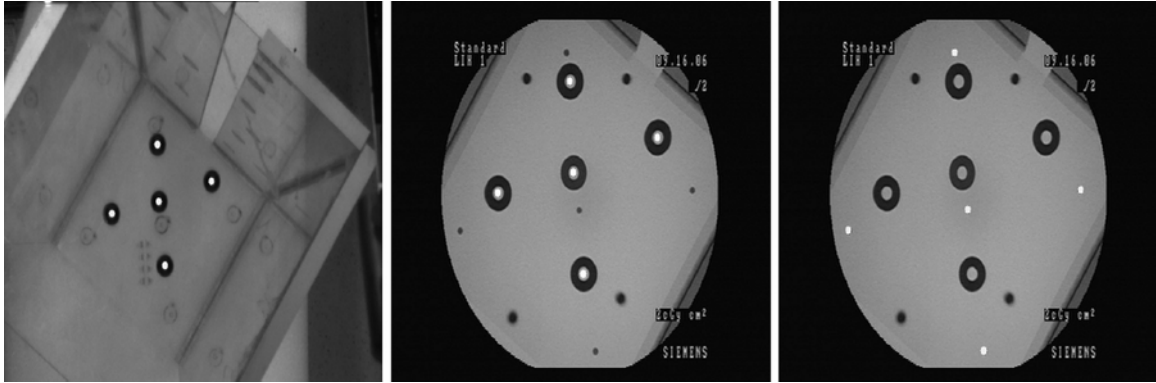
(Left): Centers of rings in the optic image displayed as white dots. (Center): Centers of rings in the X-ray image displayed as white dots. (Right): Centers of fixed biplane markers in the X-ray image shown as white dots.
